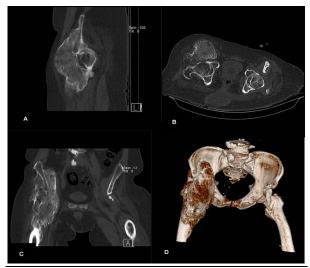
Pelvic computed tomography (CT): sagittal (A), axial (B), coronal (C), and three-dimensional (3D) reconstructed (D) perfectly showing the heterotopic ossification (HO) mass size
